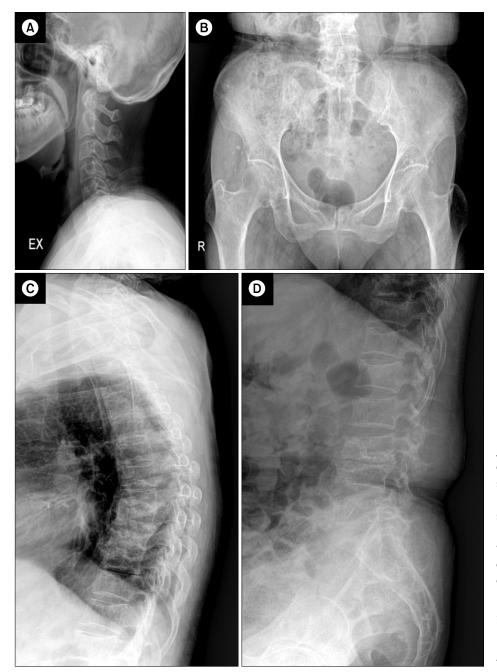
Plain radiography. Joint space narrowing with small erosion at atlantoaxial joint is observed (A) and the subtle irregular shaped bony erosions in both sacroiliac joint are shown (right > left) (B). Disc space narrowing with sclerotic marginated bony erosions are shown in the subchondral bone of from 6th to 11th thoracic vertebrae, from 2nd to 5th lumbar vertebrae and in the upper endplate of from 12th thoracic and the first lumbar vertebrae (C, D).
